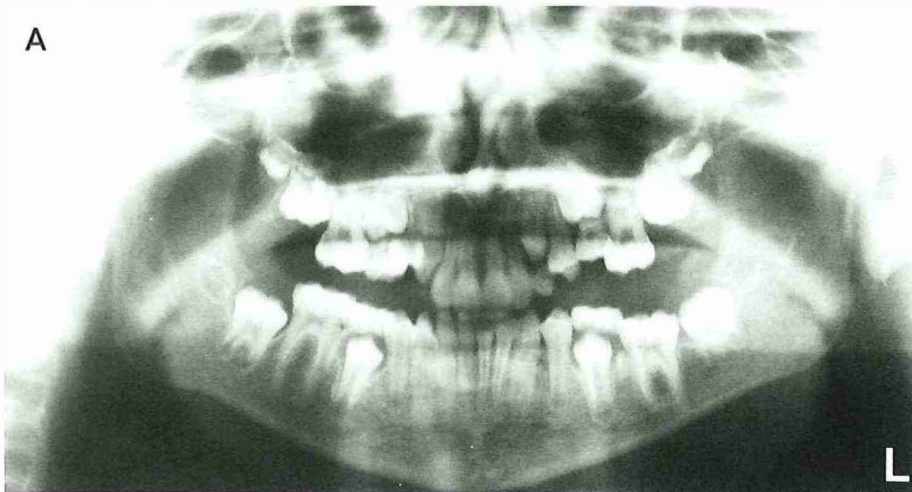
A Orthopantomogram of an 11-year-old twin showing secondary retention of the maxillary second deciduous molar and mandibular first permanent molar on the left side. B Orthopantomogram of the other twin showing secondary retention of the mandibular left second deciduous molar, and the maxillary second deciduous molar and first permanent molar on the right side.
